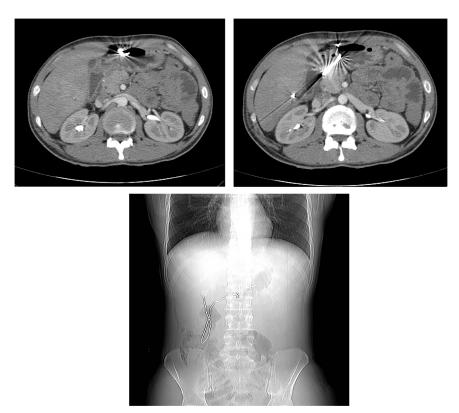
(A–C) CT scan before operation. Imaging revealed a part of the metallic wire lying in the stomach whilst the other half in the duodenum and the ascending colon.
